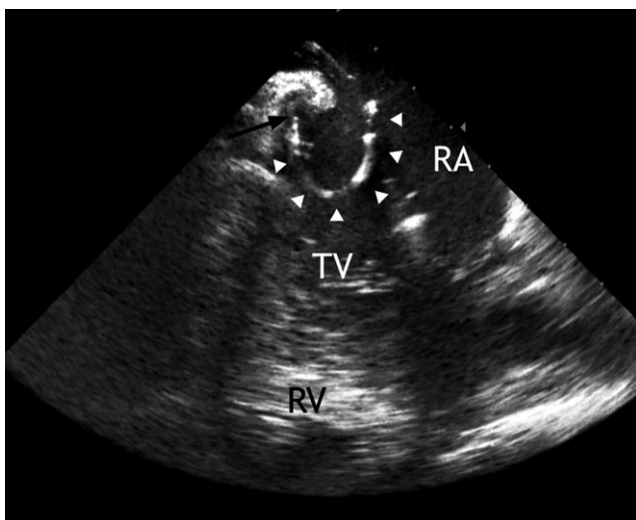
Intracardiac echocardiographic image of the "knuckle-curve ablation". The pouch depth is 7.8 mm in this case. The white arrowheads indicate the ablation catheter, of which the tip is placed deep inside the pouch (black arrow). RA, right atrium; RV, right ventricle; TV, tricuspid valve
